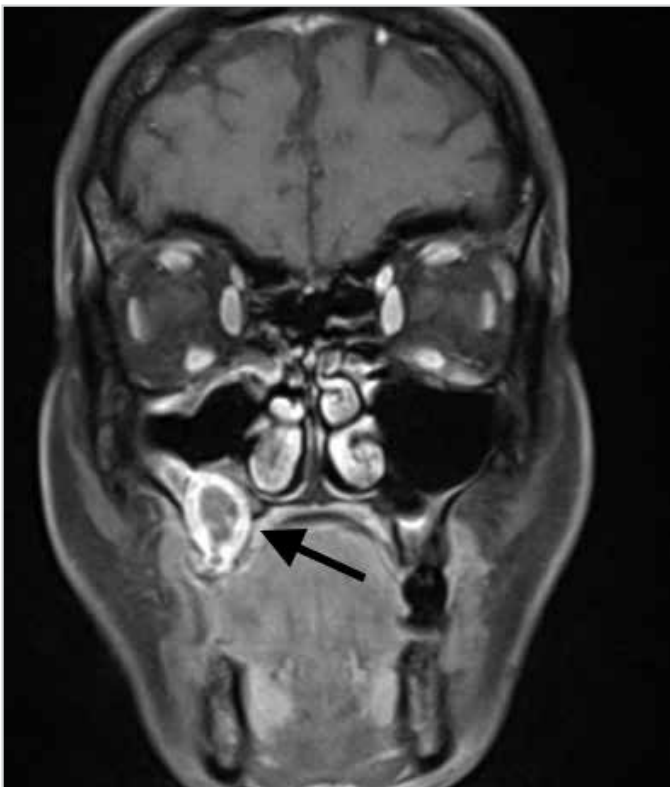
T1-contrasted coronal magnetic resonance imaging section of an expansile lytic mass lesion originating from the maxillary sinus floor
